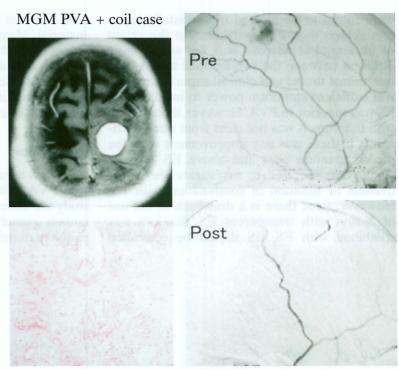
Clinical case: Meningioma; embolization using by PVA and small coil. MRI showed a well-demarcated mass. Pre-angiograms showed a 'sun-burst' phenomenon. Post-embolization angiograms showed complete embolization. Pathological findings demonstrated proximal occlusion by PVA.
